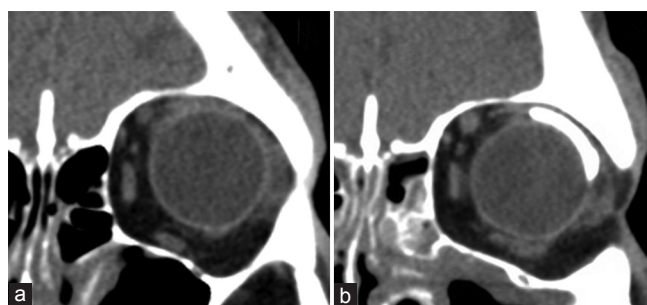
Coronal maxillofacial CT images of a 44-year-old man, shown side by side for comparison of the orbits before versus after GDI surgery. (a) Two years prior to GDI placement. (b) Same patient, 1 month after surgery, showing a localized fluid collection laterally and displacement of the lacrimal gland tissue.
